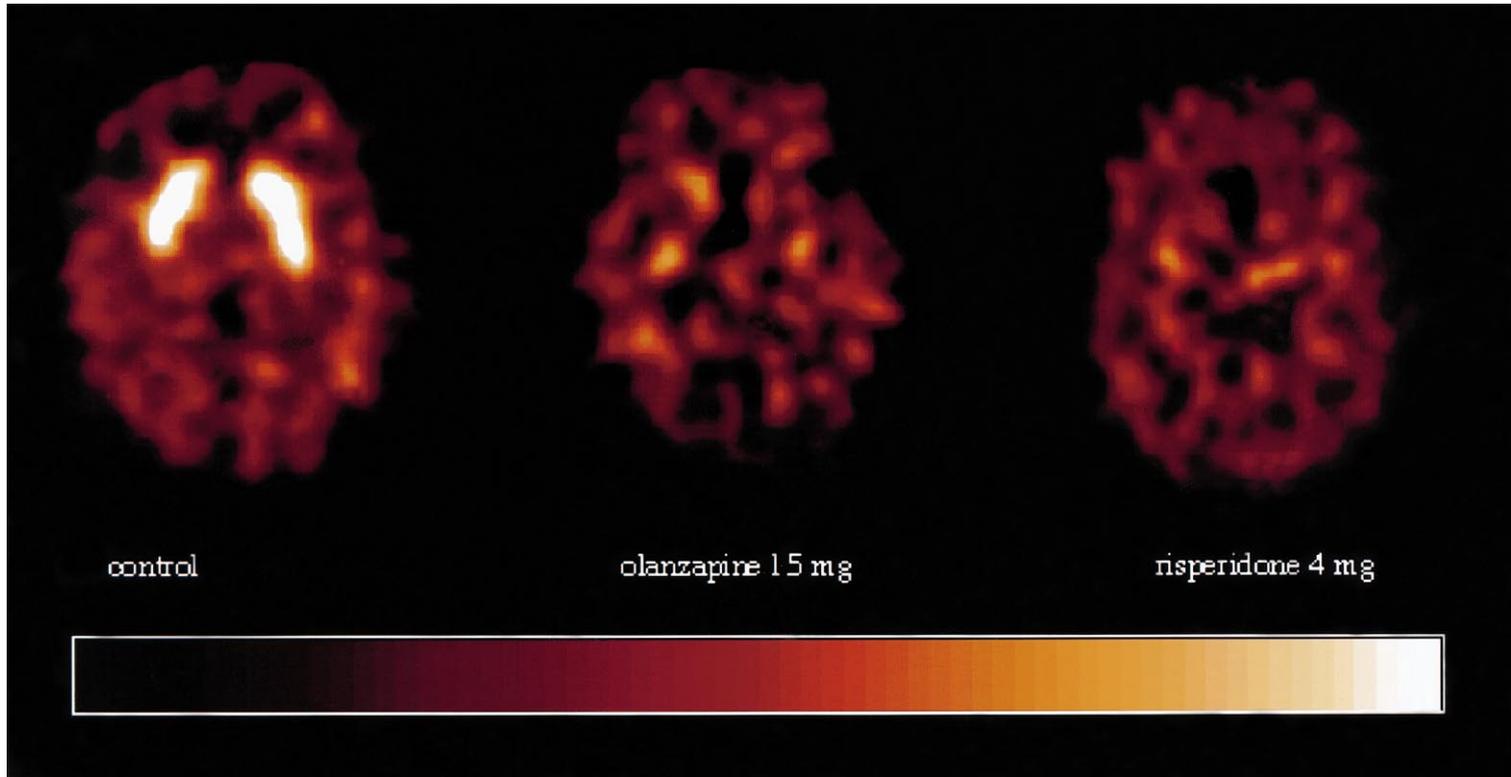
[ $^{123}\text{I}$ ]IBZM SPECT images of a healthy control and two schizophrenic patients treated with olanzapine (15 mg) and risperidone (4 mg). Transverse slices from the brain at the level of the striatum. The images of the patients clearly show much lower striatal binding of [ $^{123}\text{I}$ ]IBZM than in the control subject. Levels of SPECT activity are colour encoded from low (black) to high (white).
